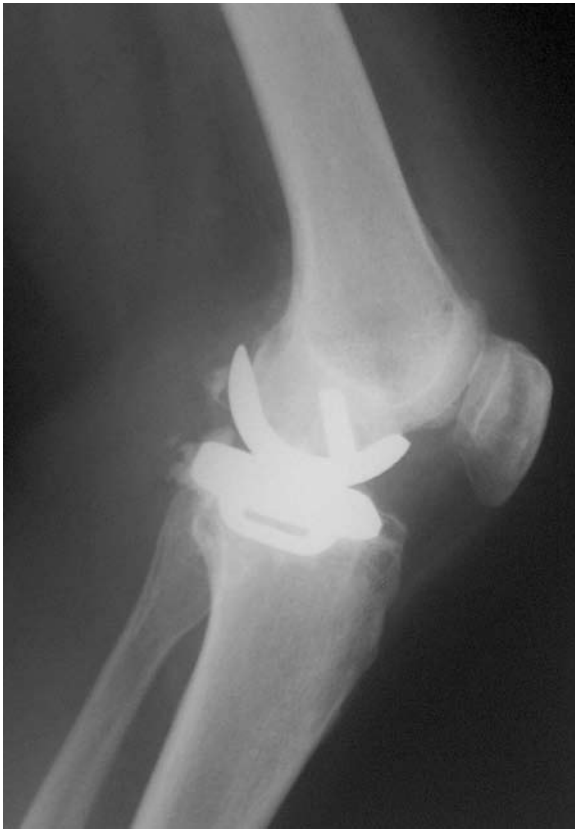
Lateral x-ray of unicompartmental knee arthroplasty with posterior cement extrusion.
